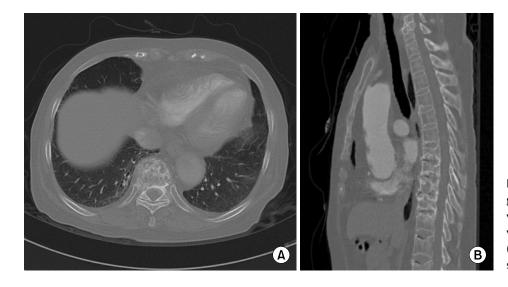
Chest computed tomography. The axial view of T10 vertebrae (A) and the sagittal view of from T7 to T11 vertebrae (B) show the endplate bony erosions and disc space narrowing.
